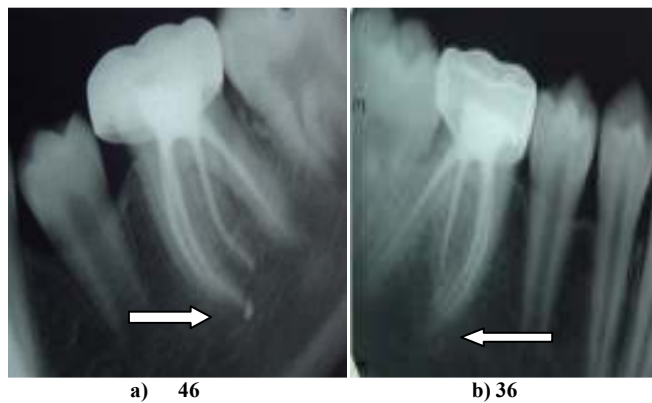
Follow up radiographs showing complete healing of periapical tissues.
